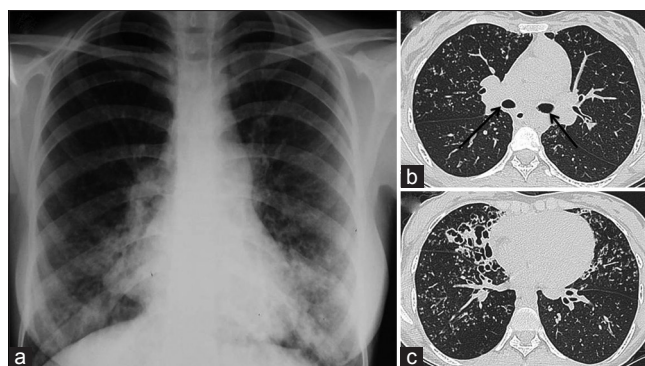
(a) Chest radiograph and (b and c) axial computed tomography images in lung window settings depicting bronchiectasis in both lungs with superadded infection. Also note the origin of both the right and left main bronchi at the same level (arrows). Both bronchi were hyparterial in origin
